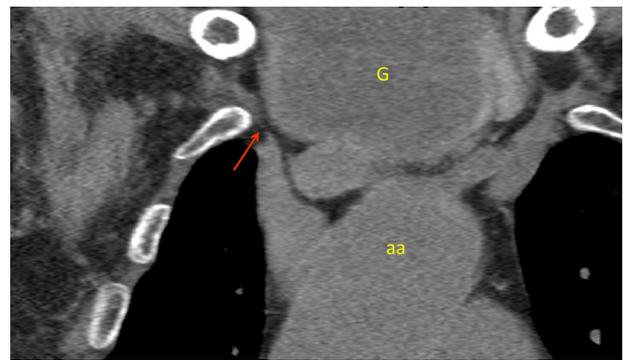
Coronal (A) and axial (B) chest CT with contrast demonstrating a retrosternal goiter (G) reaching the ascending aorta (aa) compressing the right subclavian vein (red arrow) causing filling defects.
